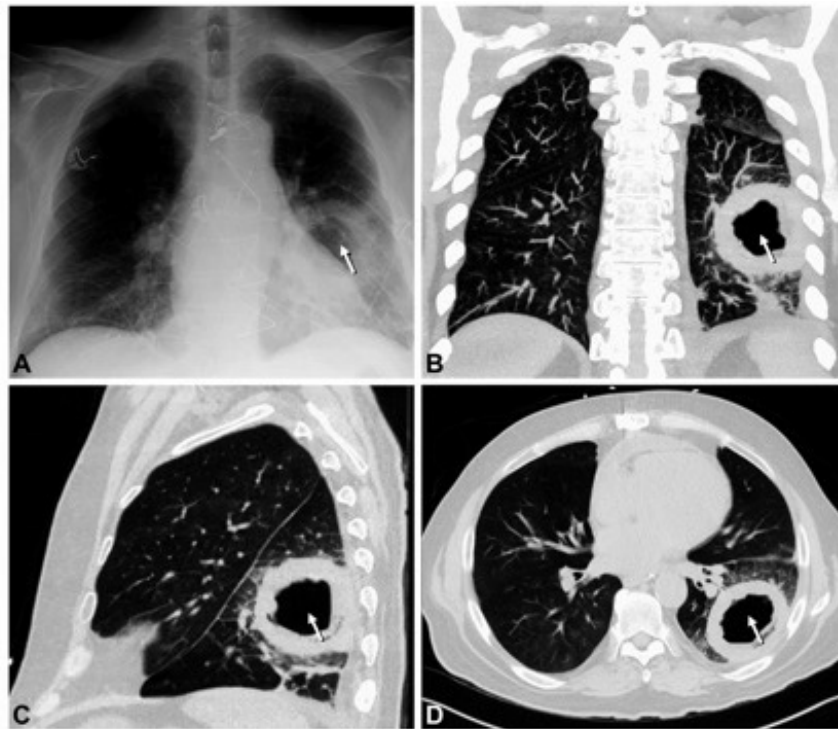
A, Chest radiograph. B-D, computed tomography scan of the chest revealing a large cavitory left lower lobe lesion with surrounding necrotic lung tissue.
